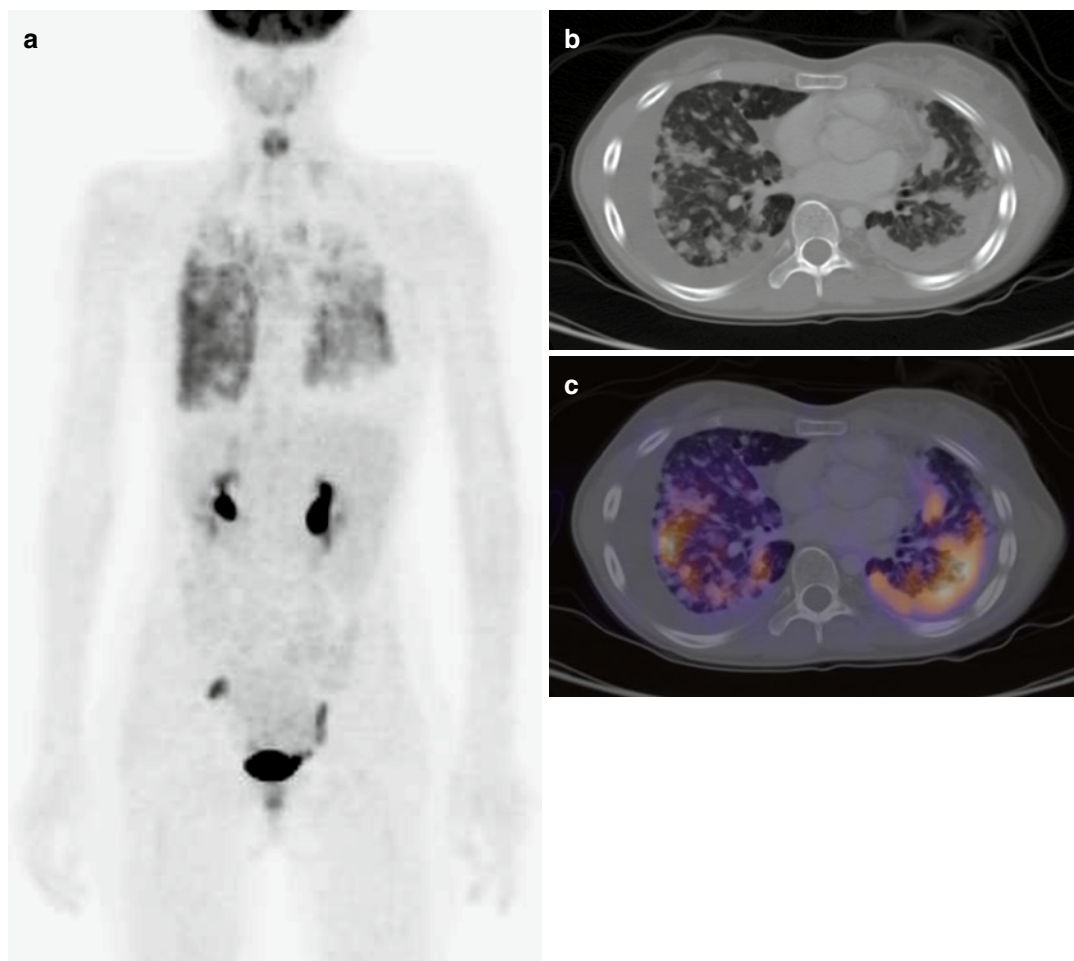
^{18}F -FDG PET of metastatic thyroid cancer. In a 13-year-old girl with metastatic thyroid cancer (see Fig. 5.15), decreasing radioiodine uptake in lung metastases despite progression of disease suggested that the metastases were losing iodine avidity. An ^{18}F -FDG PET was performed. A maximum intensity projection of the PET (a) demonstrated abnormal moderate heterogeneous uptake in both lungs. This corresponds to widespread
